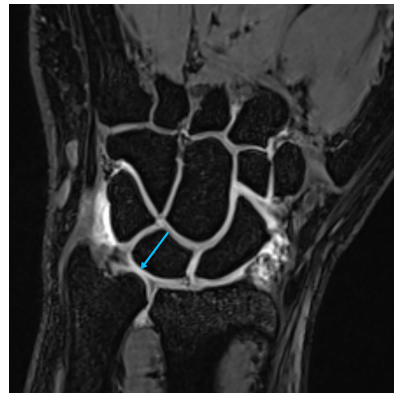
Coronal plane T1-weighted VIBE MR arthrography of the radiocarpal joint shows a central rupture (blue arrow) of the triangular fibrocartilaginous complex. VIBE, volumetric interpolated breath-hold examination; MR, magnetic resonance.
